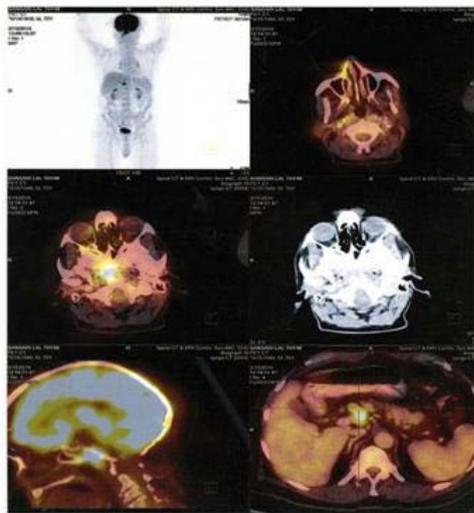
PET-CT showing FDG avid lesion in nasopharynx and FDG avid portocaval lymph node.
